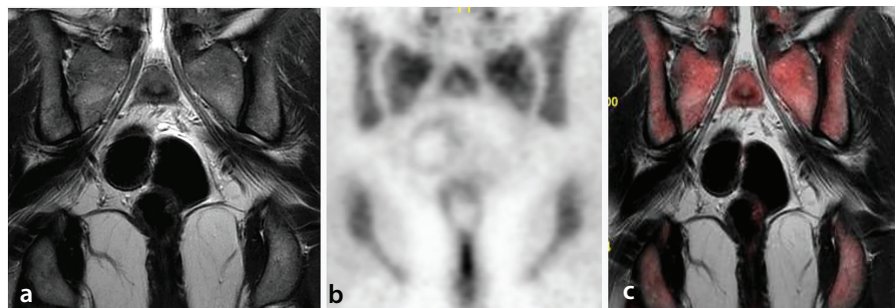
Bone marrow fluorodeoxyglucose (FDG) uptake. Pelvic bone marrow signal intensity is seen to be normal on a coronal T2-weighted magnetic resonance image (MRI) (a). The maximum intensity projection coronal positron emission tomography (PET) (b) and coronal fused PET/MRI (c) show mild diffuse uptake in the pelvic bone marrow. Mild FDG accumulation in bone marrow tends to occur as a result of benign conditions. This patient with endometrial cancer also had severe anemia and a chronic urinary tract infection.
